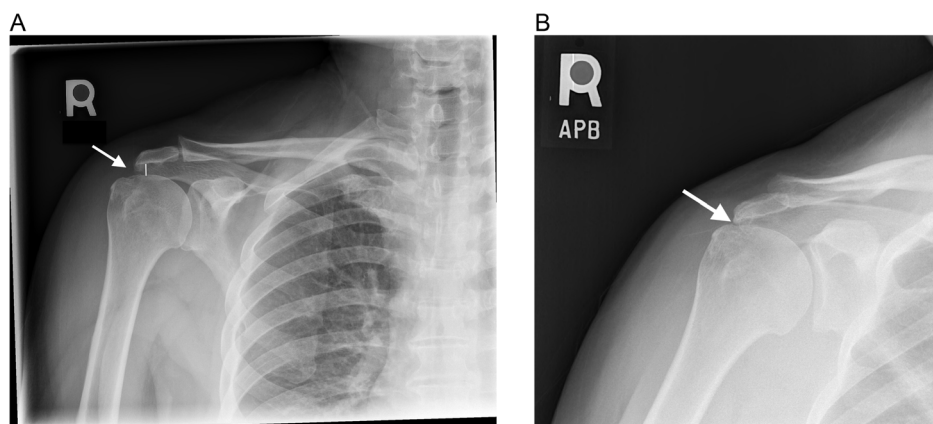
(A) Anteroposterior radiograph (AP) of the right shoulder of a patient with a massive rotator cuff tear in the resting position. White arrow showing a 9 mm acromiohumeral distance. (B) Anteroposterior, active abduction radiograph, of the same shoulder with deltoid activation showing bone-to-bone contact between the greater tuberosity and the acromion (white arrow).
